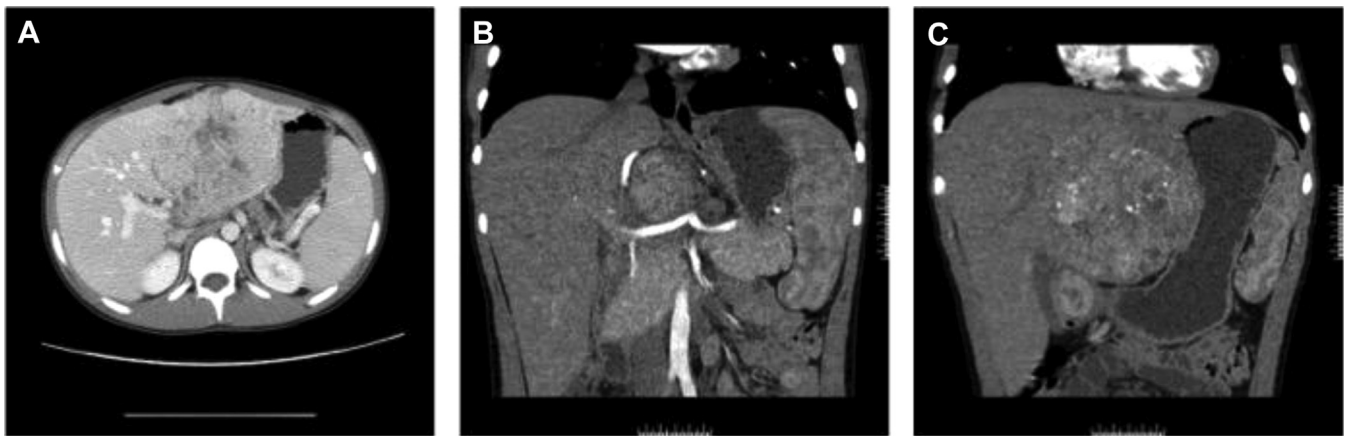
Selected images from CT scan of the abdomen showing heterogeneous lesion of the left liver in axial (A) and coronal (B and C) section.
